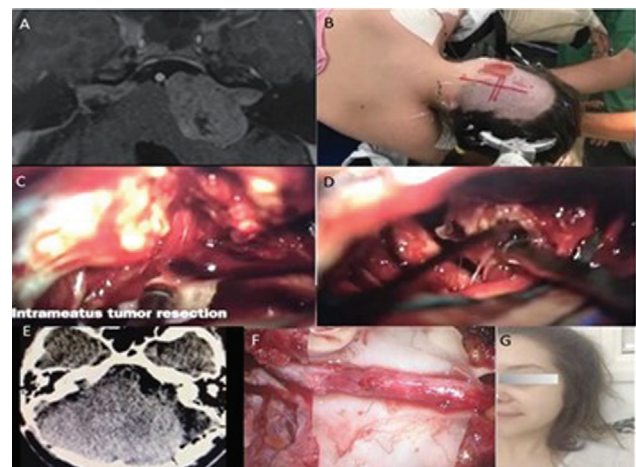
A case of a grade IVB vestibular schwannoma. (A) Gadolinium-enhanced T1-weighted axial image showing left-sided vestibular schwannoma compressing brainstem and dislocating the fourth ventricle; (B) patient's surgical positioning: $\frac{3}{4}$ prone position with shoulder retraction; (C) opened internal acoustic canal; (D) tumoral resection; (E) early postoperative computed tomography (CT) scan showing gross total tumor resection and opened internal acoustic canal; (F) intraoperative hypoglossal-facial nerve anastomosis; (G) postoperative facial motricity preservation.
